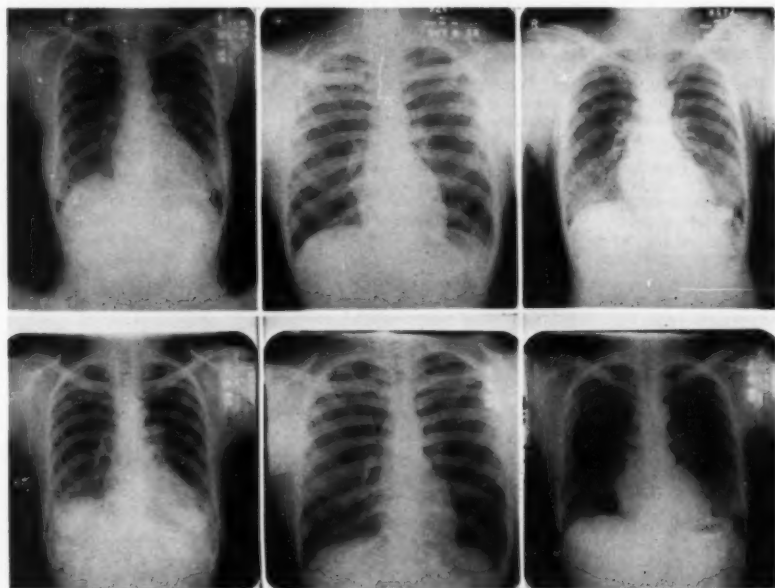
Chest radiographs of three types of patient showing exposure on 14x17 film above and corresponding 14x14 inch film below. Waste of film and unnecessary exposure is demonstrated in the upper examinations.
